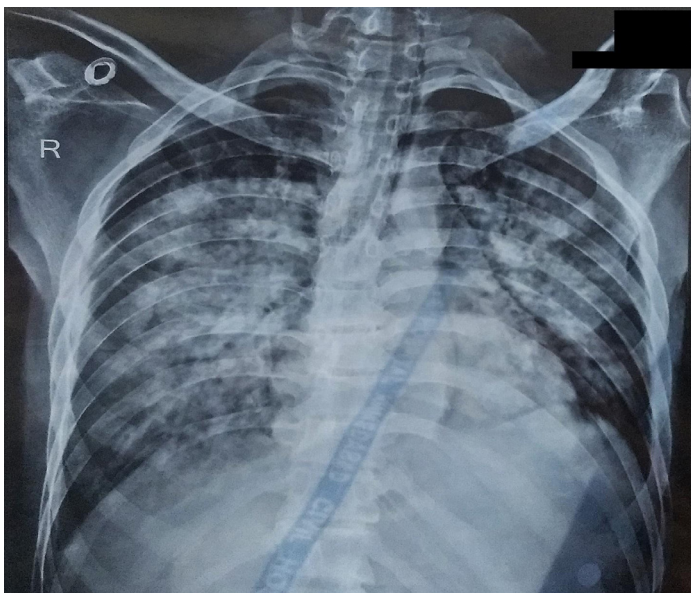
Chest X-Ray of the patient showing bat wing appearance signifying the presence of pulmonary edema.⁶
